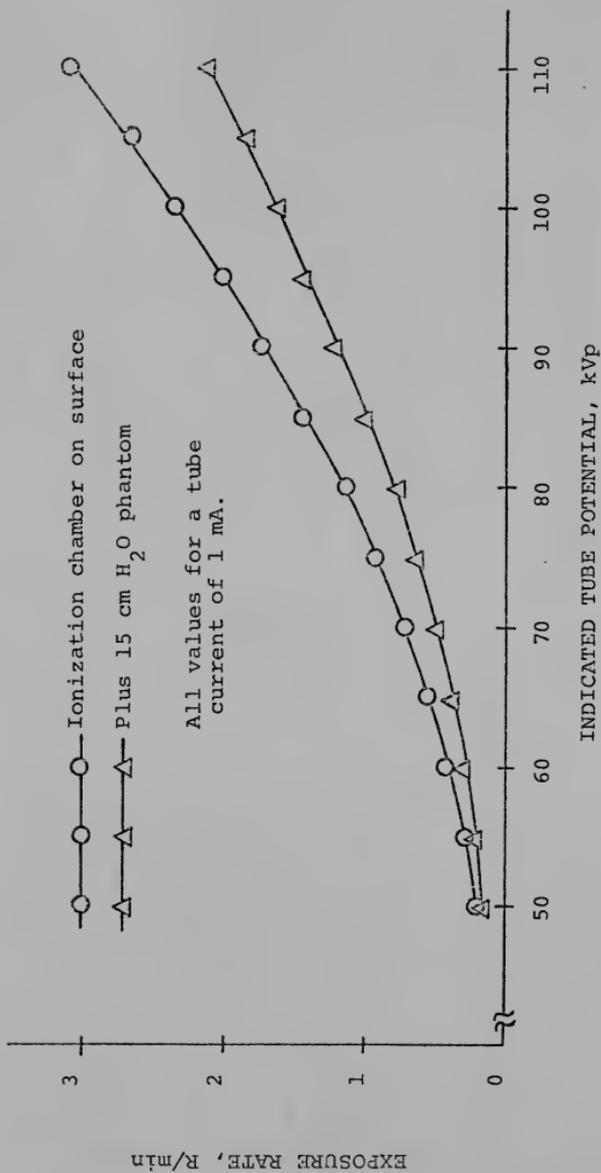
Measured Exposure Rate at Surface of Pediatric Restraint Board Positioned on Flat Table Surface from Under Table Fluoro/cine X-ray Tube.
